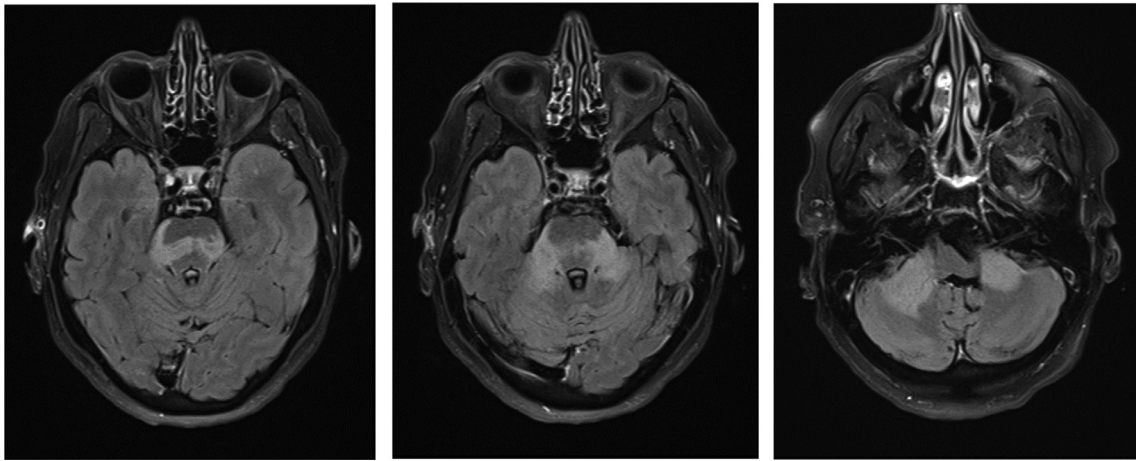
MRI brain on admission. T2 FLAIR sequences demonstrating confluent and symmetrical hyperintensity in the pons, middle cerebellar peduncles and anteromedial cerebellar hemispheres.
